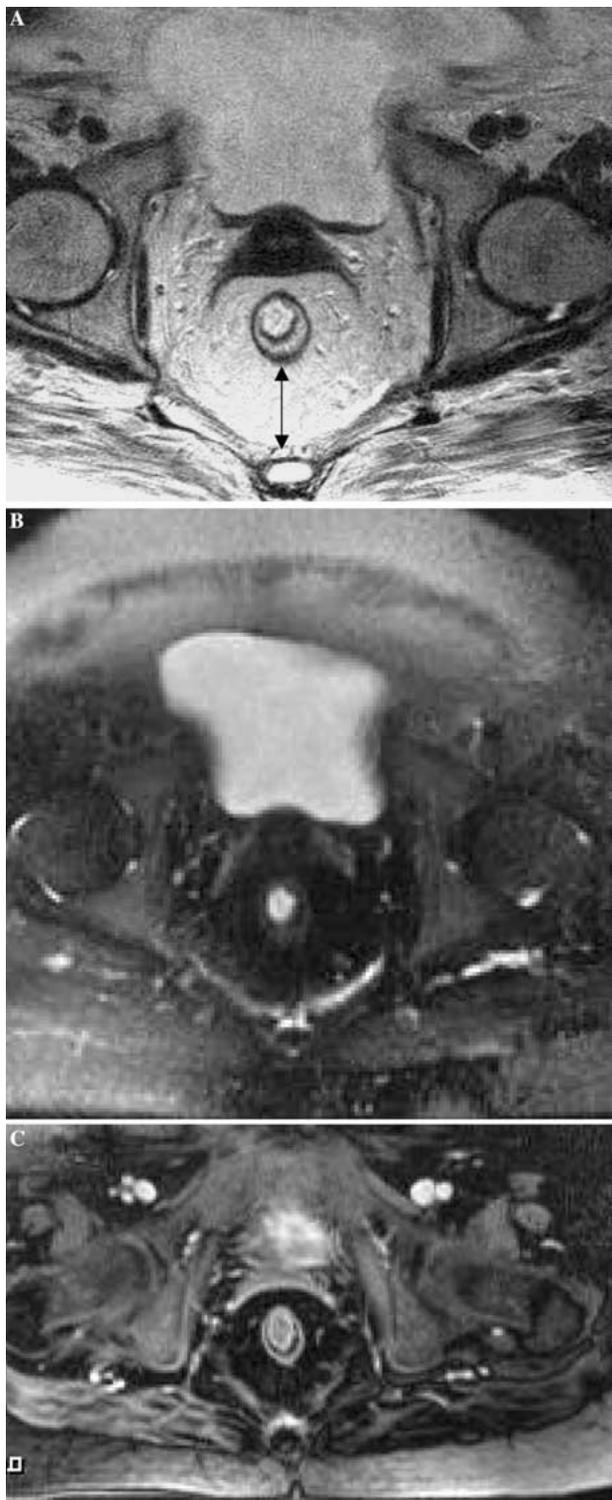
Rectum of a 60-year-old female with longstanding UC and mild symptoms and signs at clinical and endoscopic evaluations. A Axial T2-weighted high-resolution turbo spin-echo image shows diffuse thickening of the rectal wall, with widening of the presacral fat (*double-headed arrow*). Mural stratification is also evident, characterized by a bright internal line (the submucosa layer) between two dark stripes that are related to the mucosa and the muscularis propria, respectively. B Axial T2-weighted fat-suppressed half-Fourier single-shot turbo spin-echo image, obtained at the same level as A, shows complete darkening of the perivisceral fat and suppression of the wall signal, suggesting minimal inflammatory wall involvement. At the level of the submucosal layer, the brightness observed on the plain image has been completely canceled, suggesting the presence of submucosal fat. On endoscopy only a few aphthoid ulcers were observed, with sparing of most of the mucosa. C Axial T1-weighted fat-suppressed fast low-angle single-shot post-gadolinium image shows moderate wall enhancement, with complete suppression of the signal of the submucosal layer, in agreement with findings observed on T2 saturation suppressed images.
